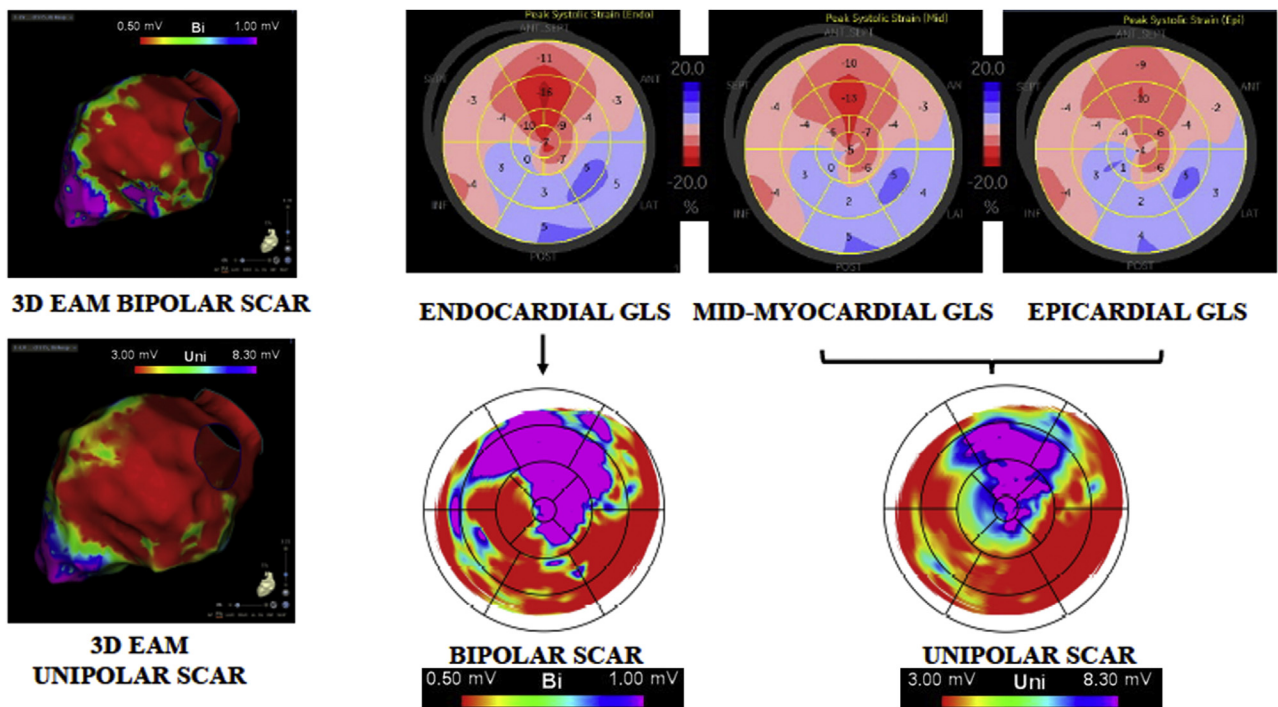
Example of a nonischemic cardiomyopathy (NICM) patient with inferolateral scar with layer-specific speckle-tracking echocardiography (STE) parameters and bipolar and unipolar scar burden on electroanatomic mapping (EAM). STE and EAM parameters in a 68-year-old woman with NICM and an inferolateral scar. Left upper panel: Three-dimensional (3D) EAM demonstrating bipolar scar. Left lower panel: 3D EAM demonstrating unipolar scar. Right upper panel: Endocardial global longitudinal strain (GLS) demonstrating impaired strain in inferolateral segments (left), midmyocardial GLS (middle), and epicardial GLS (right). Right lower panel: Bipolar scar on EAM demonstrating an extensive inferolateral scar (left) and unipolar scar on EAM (right).
